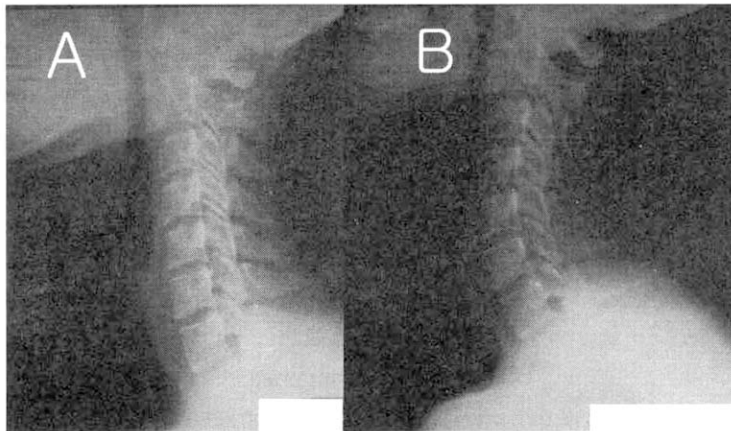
Example patient with decreased lordosis who had a return to lordosis at follow-up. (A) The patient's lateral cervical radiograph depict a decreased lordotic configuration. (B) After 25 days(8visits) of deep acupuncture treatment, the configuration is lordotic
